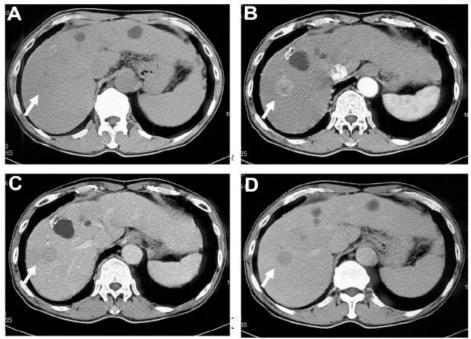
Fig with hepatocellular 8. 1: 68-year-old carcinoma in segment A man a Notes: (A) A noncontract CT image cannot clearly depict a liver nodule (arrow). (B) Arterial-phase CT image (performed with an iodine concentration of 300 mg I/mL) shows a hyper attenuating nodular lesion in segment 8 (arrow). (C) On portal-phase CT imaging, the lesion is depicted as hypo attenuating nodule (arrow). (D) An equilibrium-phase CT image shows a discrete hypo attenuating nodule (arrow). On combination of four-phase image sets, the lesion is definitely diagnosed as typical hyper vascular hepatocellular carcinoma.
